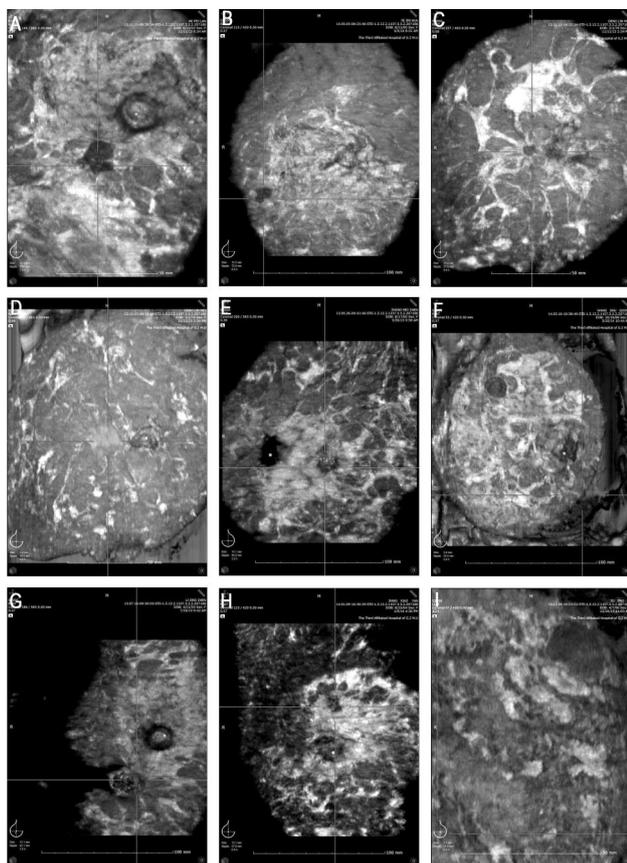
Coronal ultrasonography by automated breast volume scanning in benign and malignant lesions.
